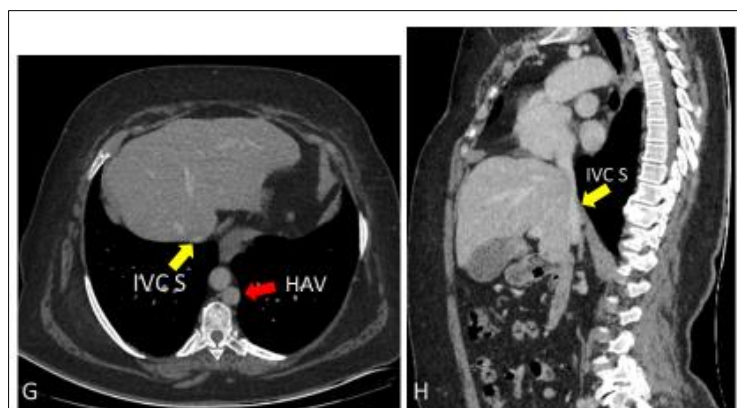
Axial (G) and oblique sagittal (H) CT images showing the short retro/transhepatic inferior vena cava segment (yellow arrow). The hepatic veins converge into this residual caval segment, which drains into the right atrium. IVCS = short inferior vena cava segment; HAV = hemiazygos vein
